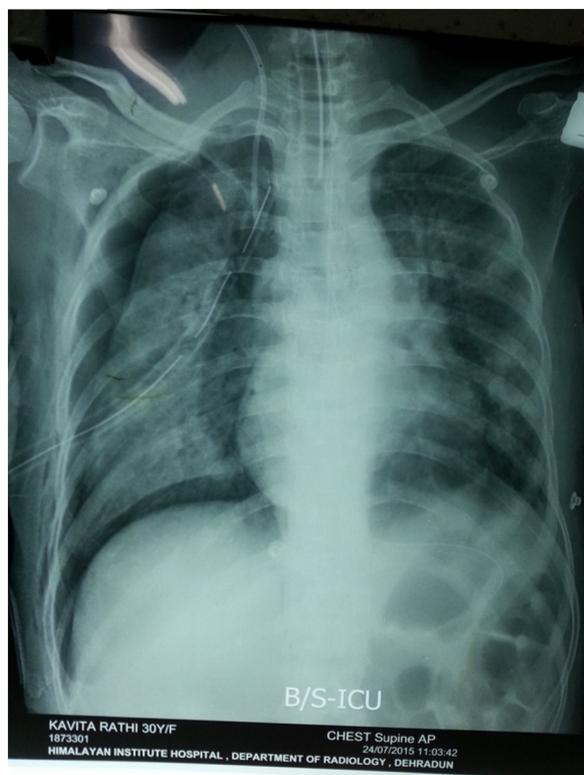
Chest X-ray of patient showing right-sided pneumothorax with underlying ground glassing with ICT in situ.
